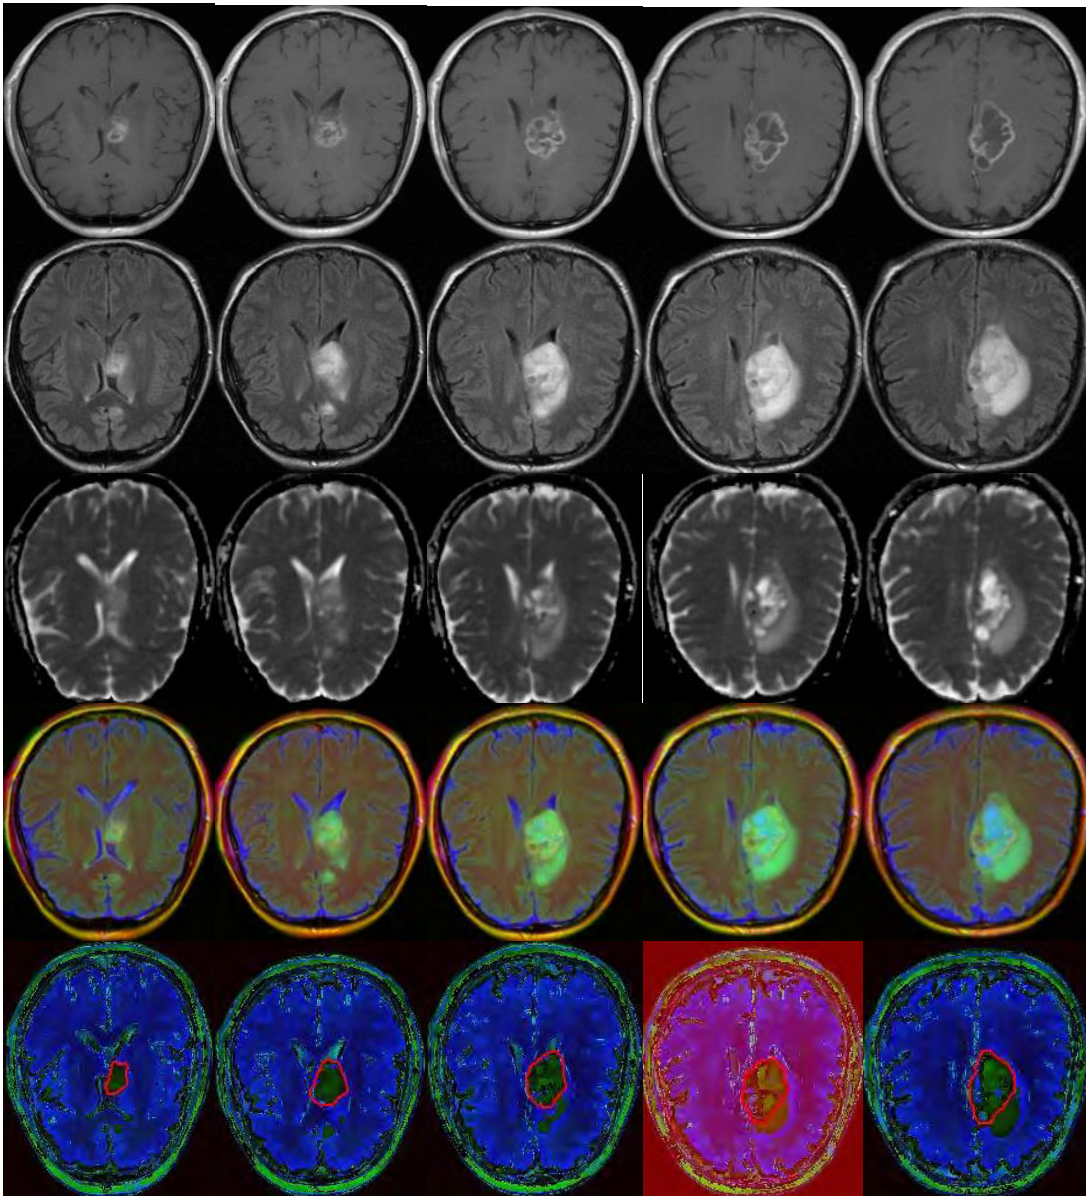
Original T1W, T2-FLAIR, and ADC images (rows 1 to 3), combined color image (row 4), and generated signature map (row 5). Red Lines denote the expert tumor delineations.
